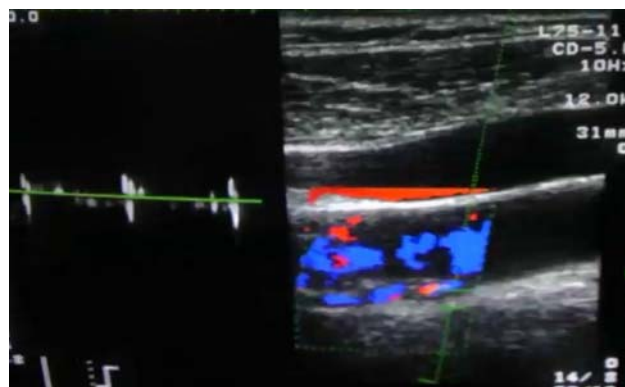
Doppler ultrasound of carotid arteries. Biphasic flow of the right common carotid artery.
